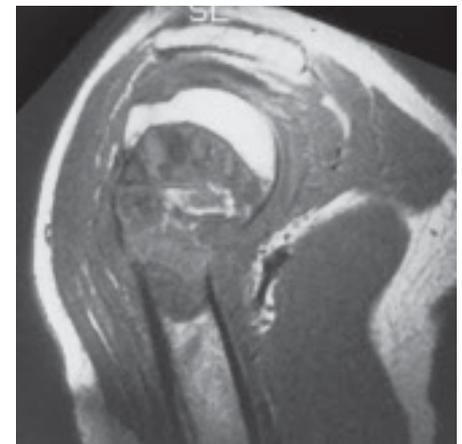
Giant cell tumour of the proximal humerus. MRI shows a well demarcated lesion with focal destruction of cortex and extension into the epiphysis.
